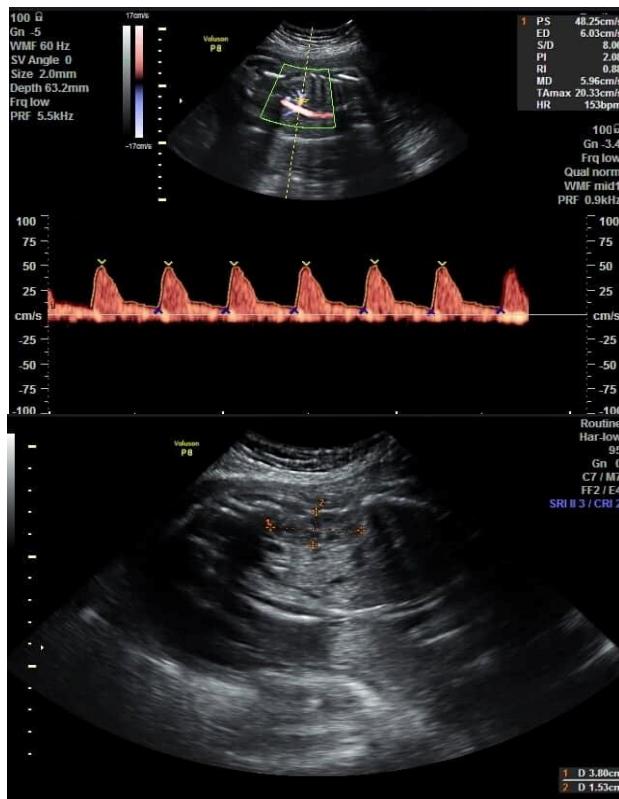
Ultrasound of IUGR fetus aged 32 weeks show renal measurements and fetal renal Doppler
